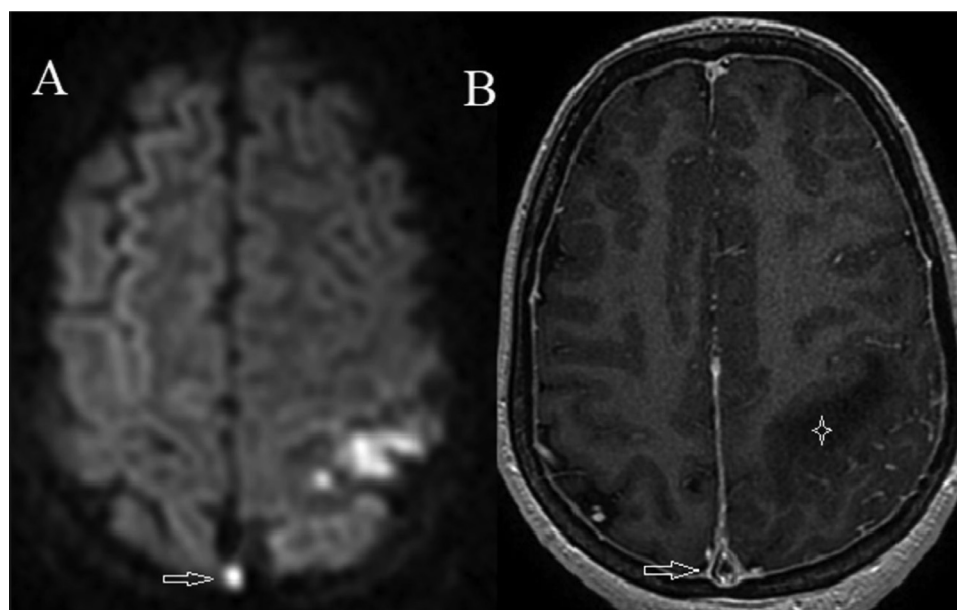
Cerebral MRI on diffusion sequence (A) shows high signal intensity of the left parietal lobe with punctiform hyperintensity of the superior sagittal sinus (arrow). Axial T1 contrast-enhanced sequence (B) demonstrates delta sign of the superior sagittal sinus (arrow) with hypointensity in the left parietal lobe (asterisk).
